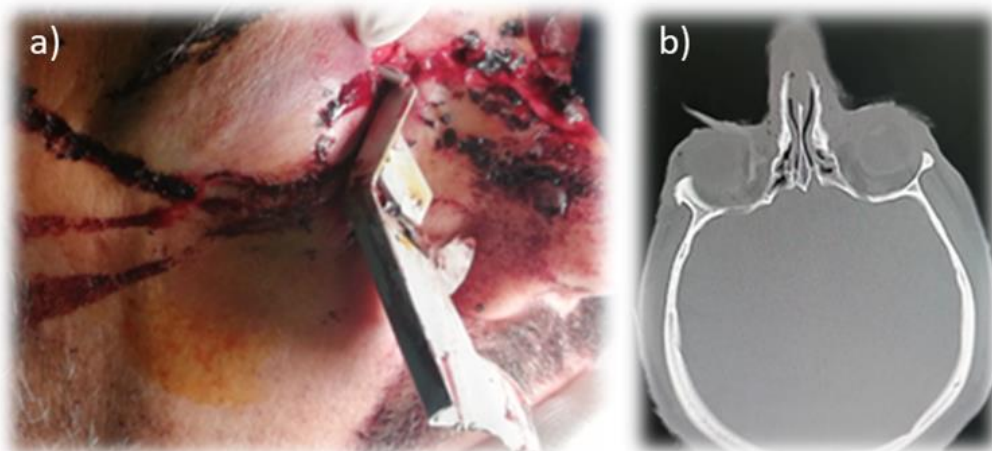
a) Initial presentation of the patient, b) CT of the head, in the region of the medial part of the right orbital penetrating foreign body
